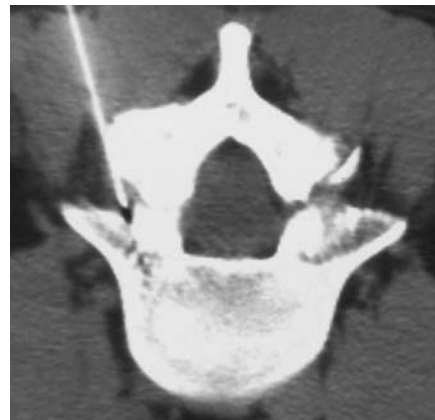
A 31-year-old man was referred to us with several years' history of bilateral back pain and sciatica mainly on the right caused by Meyerding's first grade spondylolisthesis and bilateral isthmic lysis demonstrated on multiple radiograms (standard x-rays, CT and MR scans) which also disclosed accompanying marked concentric protrusion of the intervertebral disc with involvement of both root canals. No sensory or motor deficit was evident and for this reason none of the specialists consulted by the patient had proposed stabilizing surgery by means of intersomatic arthrodesis with interpedicular osteosynthesis.
